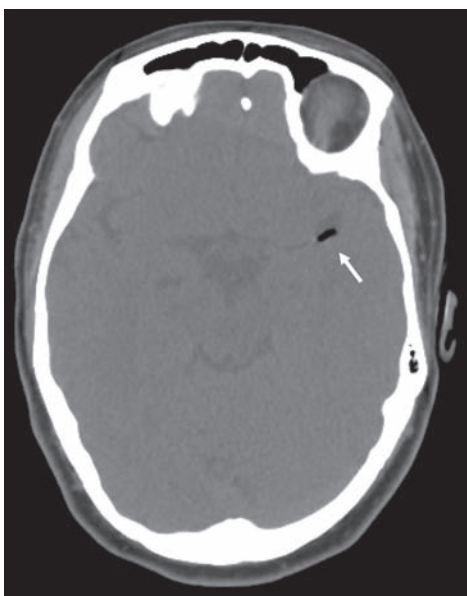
Computed tomography demonstrating an air embolism in the left middle cerebral artery distribution (arrow)
